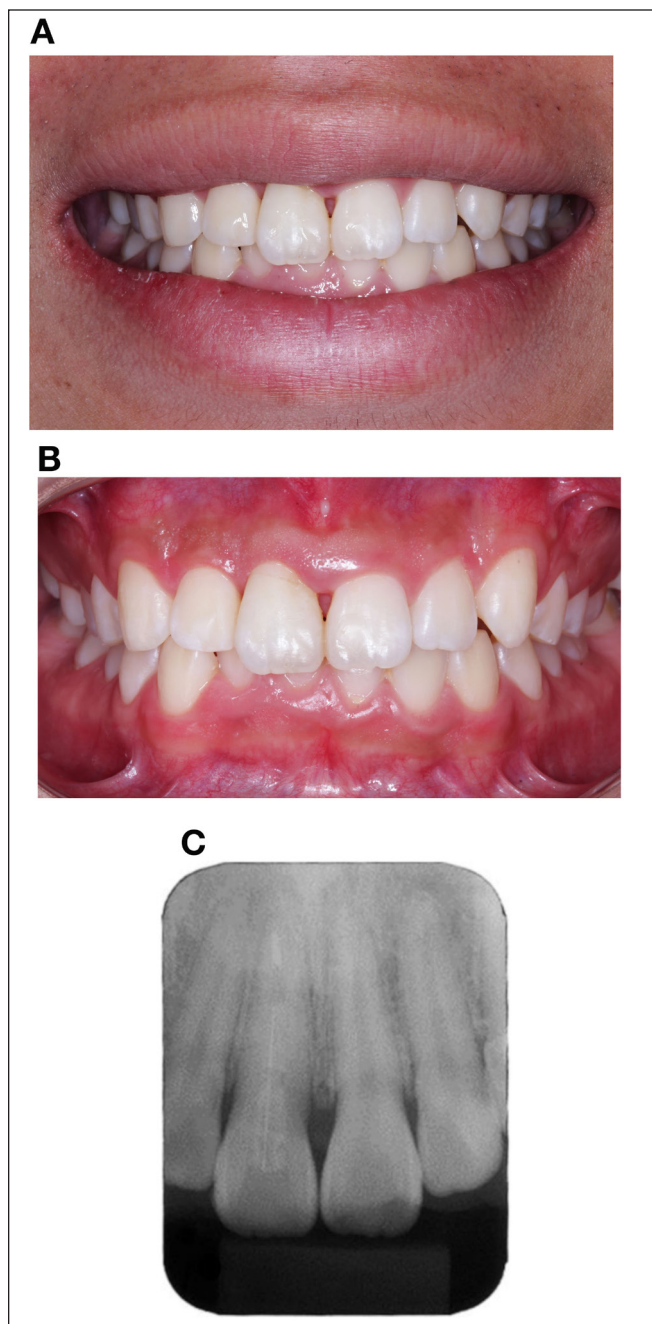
Follow-up at 49 days. (A) Front view of the smile: the fracture line does not appear significantly; (B) Close front view; (C) Radiographic follow-up.
